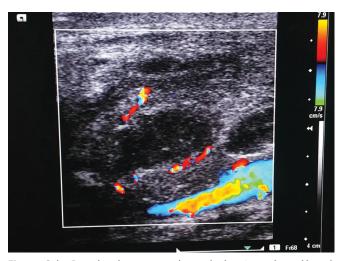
Color Doppler ultrasonography study showing enlarged lymph node with absent hilum and peripheral vascularity
